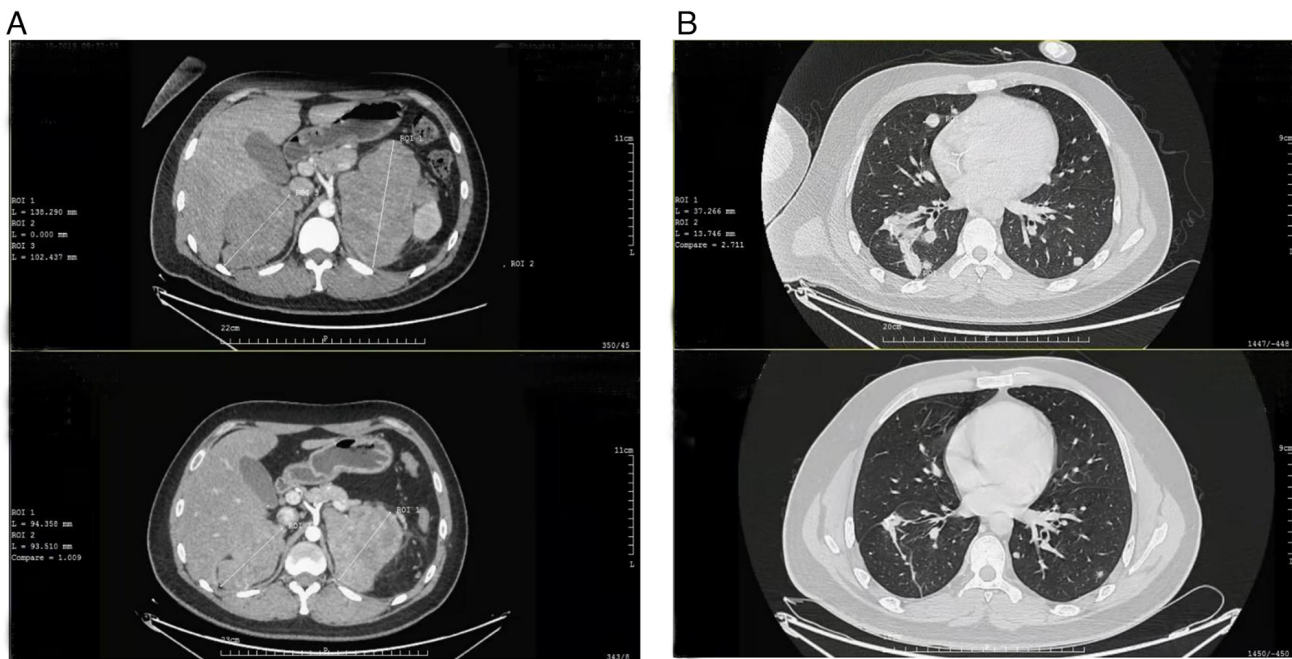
(A) CT-scan images indicated multiple metastatic lesions in adrenal glands at the baseline assessment (February 2019) and after treatment with anti-PD-1 therapy (June 2019; right, 102 mm reduced to 93.5 mm; left, 138 mm reduced to 94 mm). (B) Bilateral pulmonary lesions at the baseline assessment (February 2019) were reduced or even disappeared after treatment with anti-PD-1 therapy (June 2019). PD-1, programmed death receptor 1.
